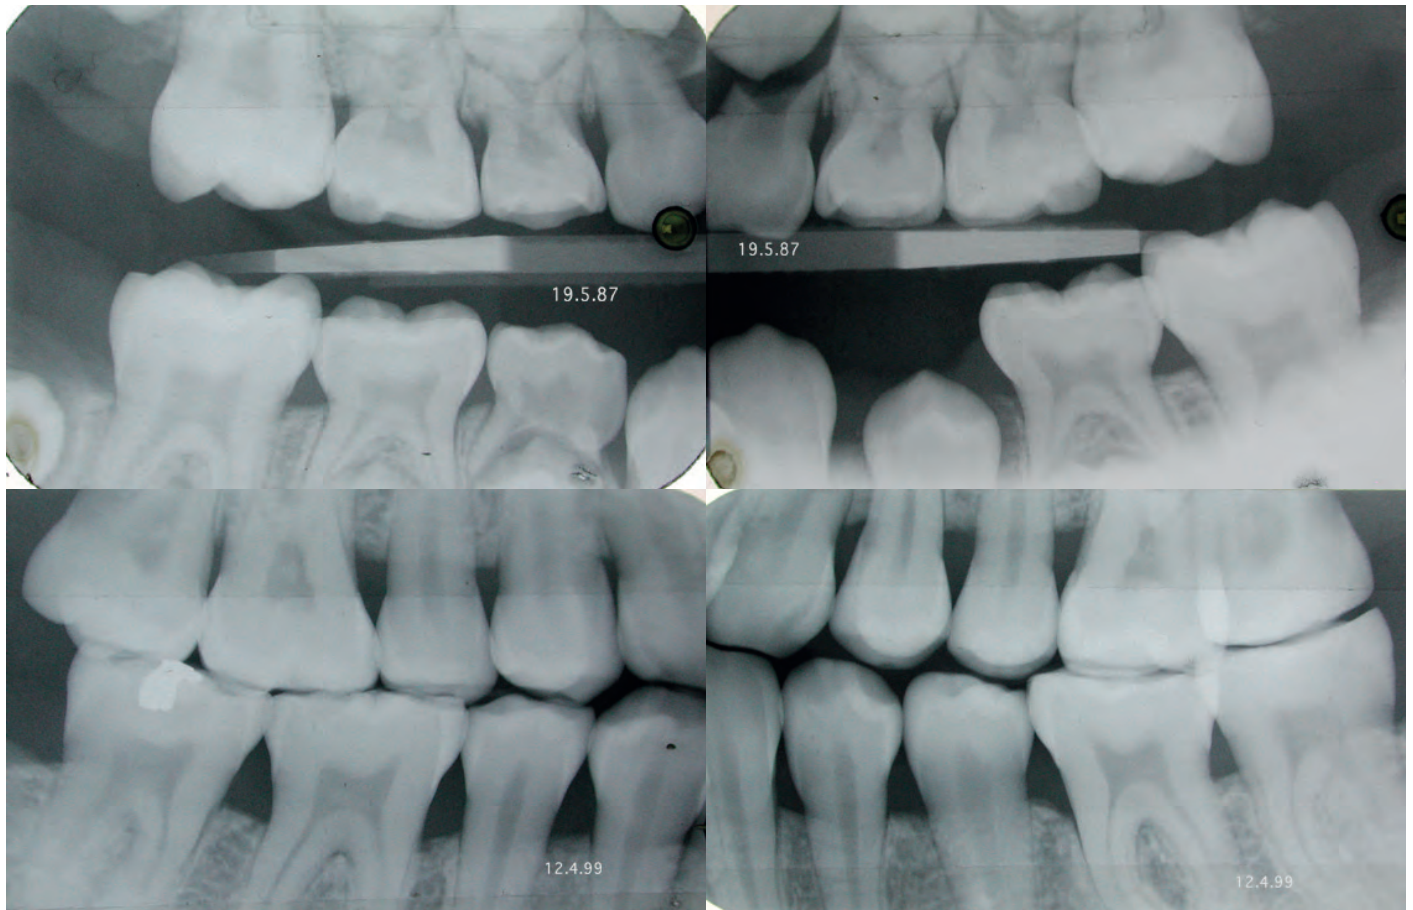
Upper row: X-ray images of a 10-year-old (1987 with caries prevention campaign). Lower row: same person, 22 years old, with a single filling in April 1999. (Collection of U. P. Saxer)
